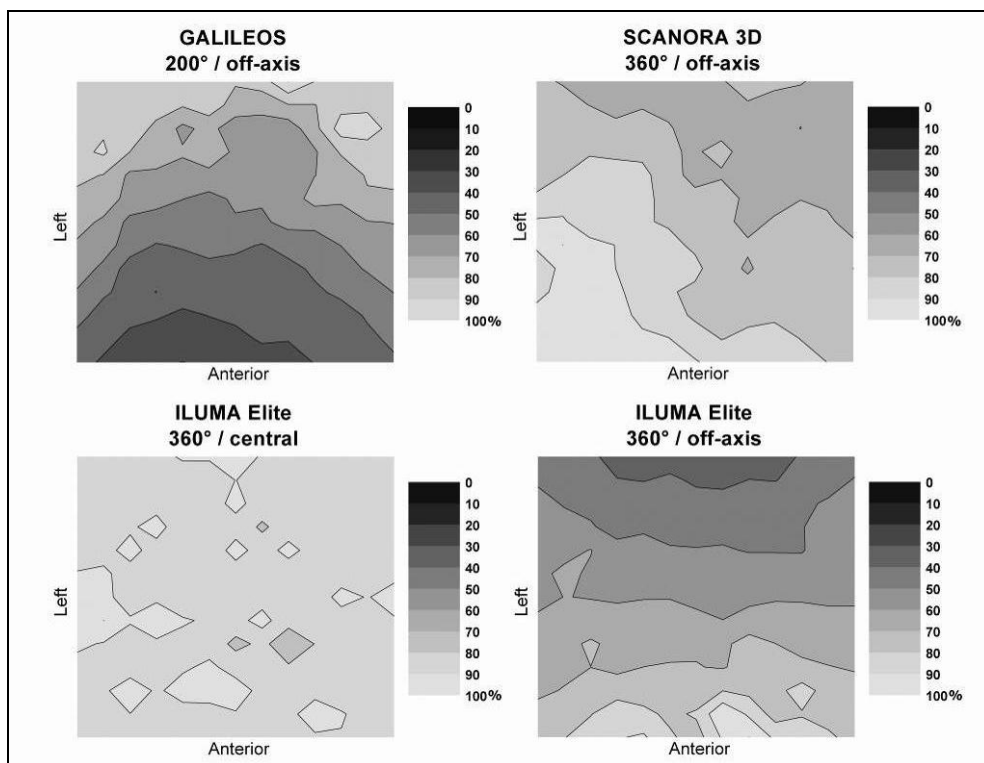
Relative dose distributions (%) at the x-y plane in water for different CBCT units and exposure settings.
